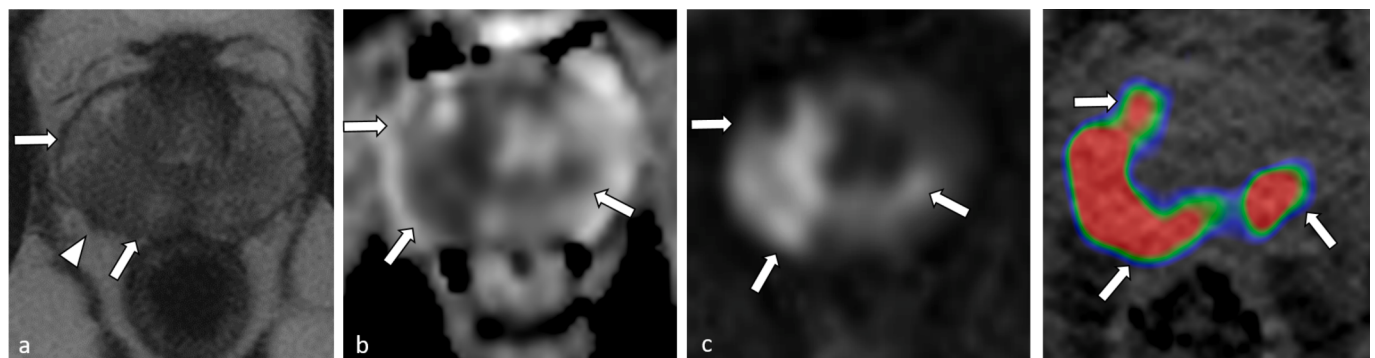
Discordant local extension between fast “All-in-One” WB-MRI and ^{68}Ga -PSMA-PET/CT, in a 49 year-old man with a PSA = 32.6 ng/ml who benefited from a RP. Biparametric MRI based on on axial T2-weighted images (a), and axial DWI ($b = 2000 \text{ s/mm}^2$) with an ADC map (c) showed a large PI-RADS 5 lesion infiltrating the right and left lobes (arrows), with low Signal Intensity on T2, restricted diffusion and right posterolateral EPE (arrowhead; EPE2; TCL 41 mm) confirmed pT3a at RP (c). The corresponding transverse section of fused ^{68}Ga -PSMA-PET/CT was not able to detect EPE (d).
